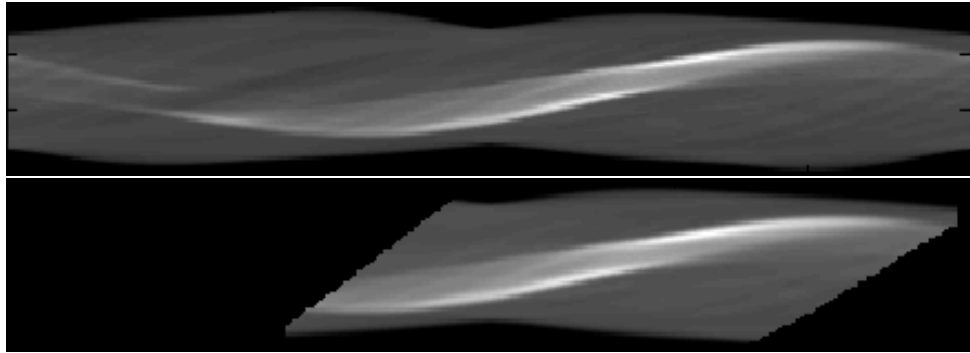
Full 360° sinogram and sinogram masked to produce pseudo-DSPECT geometry
